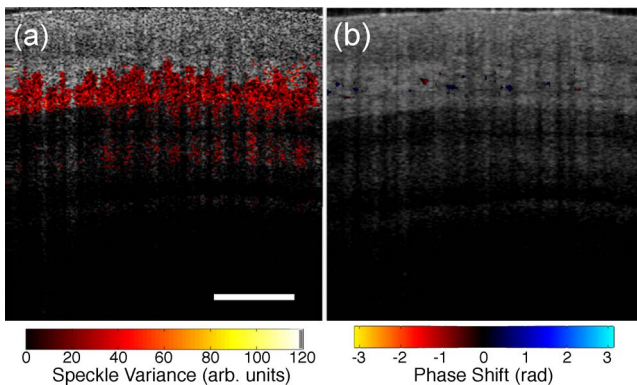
(Color online) *In vivo* imaging in a high BTM situation: (a) structural image of human nail root with SV data overlay (Media 1), (b) structural image from the same location with color Doppler image overlay. (The scan head was tilted by 10° relative to the surface of the finger, providing a Doppler angle of $\sim 80^\circ$.) (Media 2) Field of view is $2 \times 2 \text{ mm}^2$. Scale bar = $500 \mu\text{m}$.
